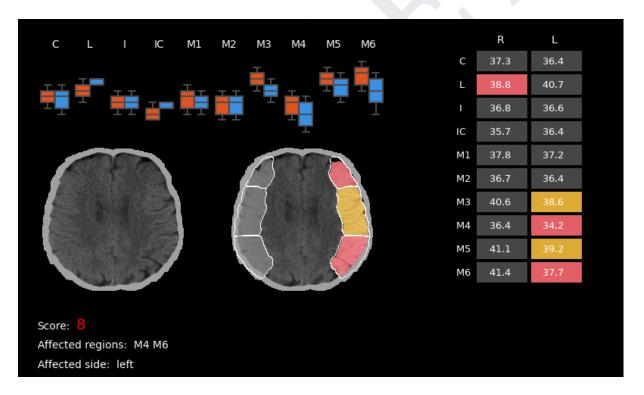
Example of StrokeViewer ASPECTS output. Regions in yellow indicate potentially affected (their HU difference approaches the predefined threshold to be considered affected) while those in red have a HU difference above the threshold and are considered affected.
